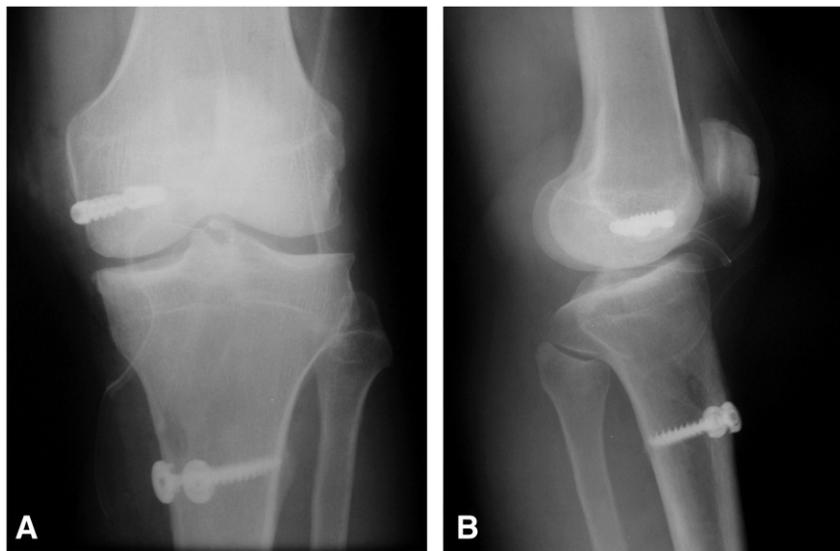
Radiograph showing the graft fixation. A) Anteroposterior and B) profile incidences.
